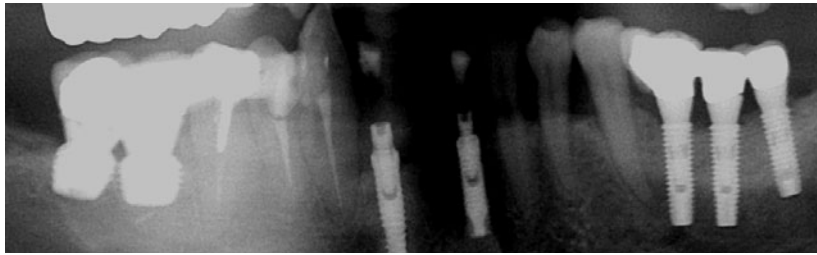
Panoramic radiograph of a patient randomised according to a split-mouth design to receive 5 mm long and 6 mm wide Rescue implants on one side and longer EZ Plus implants in bone vertically augmented with an interpositional Bio-Oss block on the other side of the mandible.
